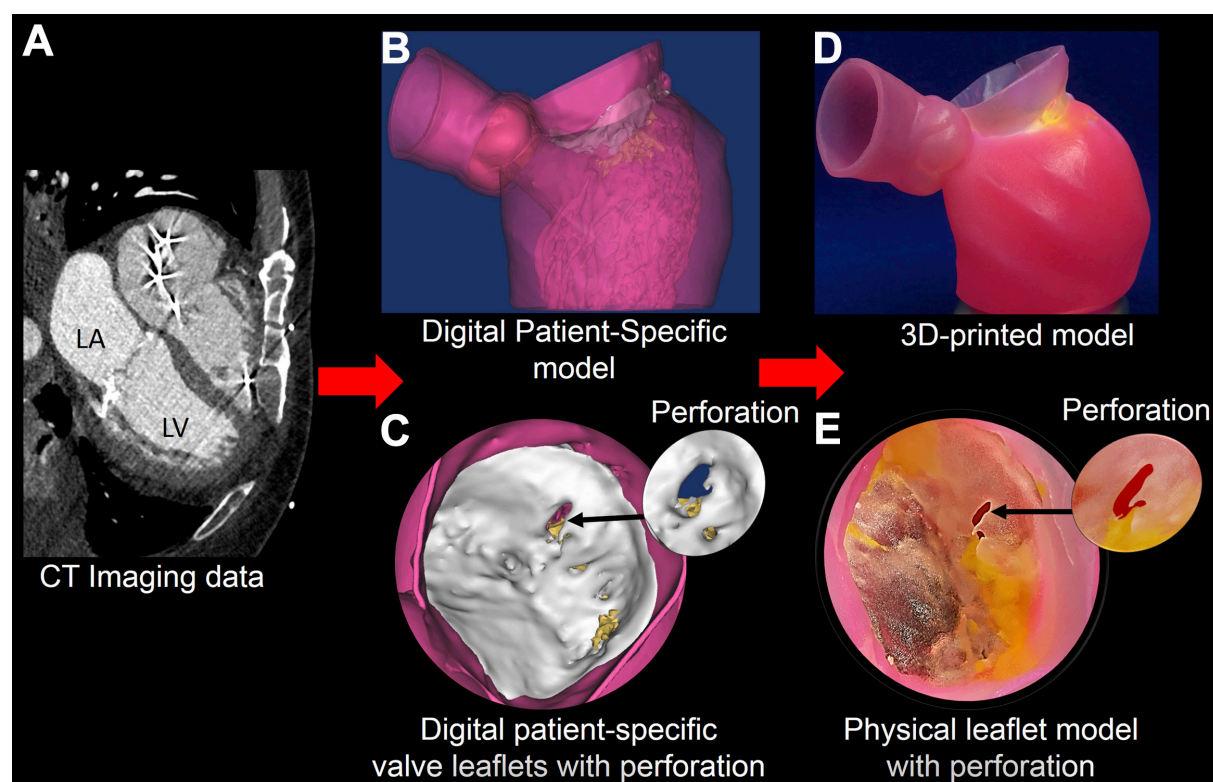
CT images (A) are used to create a digital model (B) and to assign tissue properties (C); the multi-material patient-specific 3D model (D, E) is then printed to replicate the mitral valve leaflet geometry, regional calcium deposition, and pathology. Reprinted with permission from Little *et al.*^[16]. CT: computed tomography; 3D: three-dimensional
